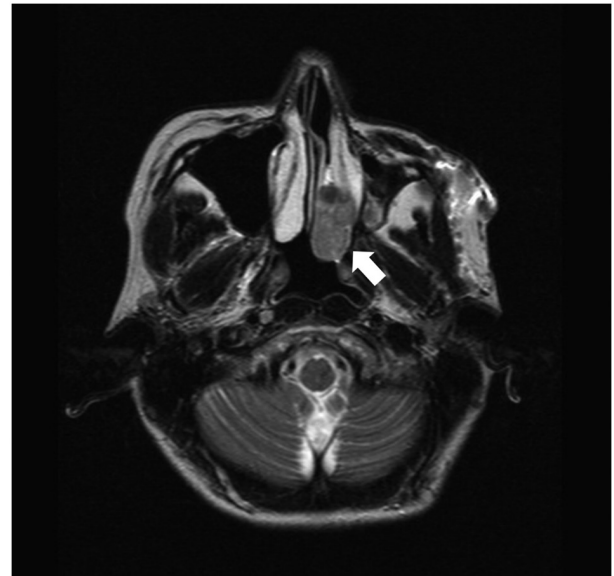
T2-weighted axial image of magnetic resonance imaging before the operation. A mild high intensity mass was recognized in the left nasal cavity (white arrow).
